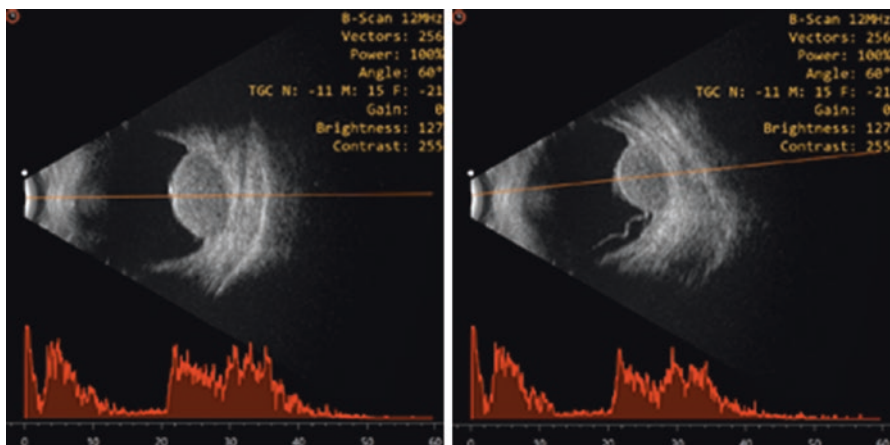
Ultrasound image of a patient with choroidal melanoma showing a dome shaped lesion on B-scan, kappa sign on A-scan, and associated retinal detachment
